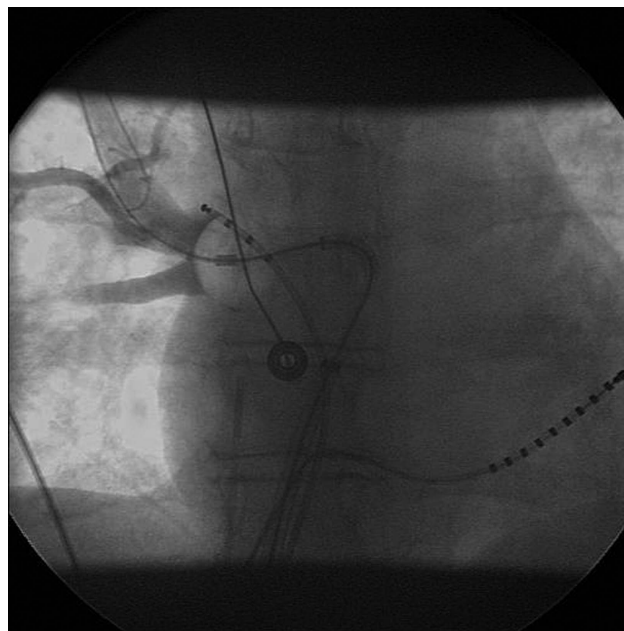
X-ray while contrast fluid is injected, showing occlusion of the right superior pulmonary vein with the cryoballoon catheter. Quadripolar pacing catheter in the superior vena caval-right atrial junction. Multipolar mapping catheter in the coronary sinus. In the mid-right-atrium, an intracardiac echo catheter is visible.
